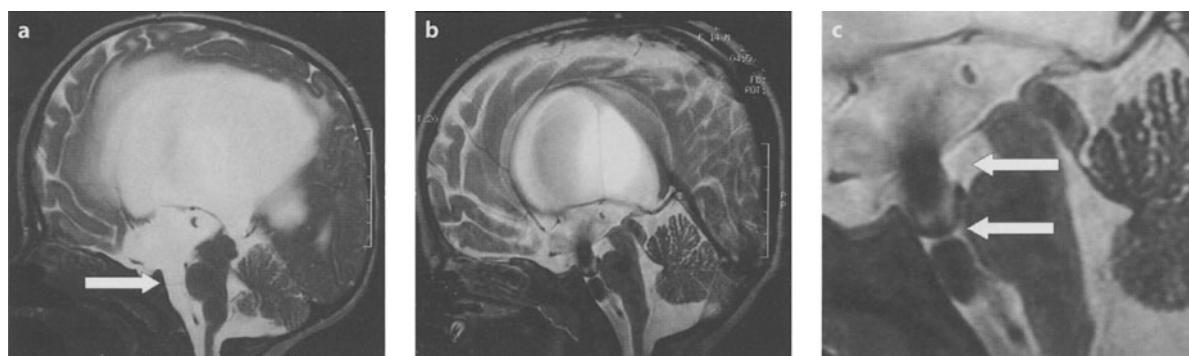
a Aqueductal stenosis in a 12-month-old baby girl. Note the position of the floor of the third ventricle, bulging almost 1 cm below the level of the posterior clinoid (arrow). b Postoperative MRI. The perforated floor is now in its normal position, well above the level of the posterior clinoid. Flow artifact is clearly visible through the third ventriculostomy and through Liliequist's membrane, visible in the detail shown in c as a thin membrane dividing the prepontine cistern into two compartments. The anterior edge is attached on the posterior aspect of the clivus; the membrane can be followed through the prepontine cistern to the anterior margin of the pons (lower arrow) and then upward into the interpeduncular cistern (upper arrow)
